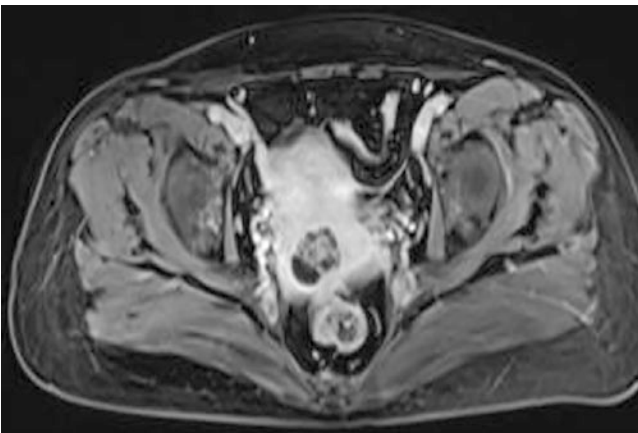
Axial contrast-enhanced fat-suppressed T1-weighted image. In this image, part of the cyst wall or septation was slightly thickened and irregularly enhanced, with no obvious solid component enhancement
